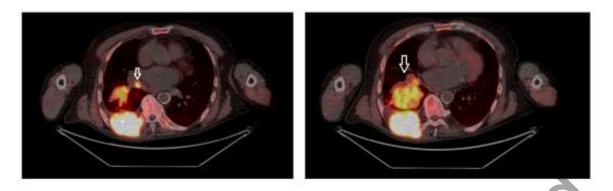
The left image shows a nodular lesion within the lumen of the right lower lobe bronchus with increased FCH uptake (white arrow) (SUVmax 10.4), while the right image shows a soft-tissue mass continuous with the nodular lesion seen on the left (SUVmax 10.4), also demonstrating increased FCH uptake — consistent with pulmonary carcinoid.
